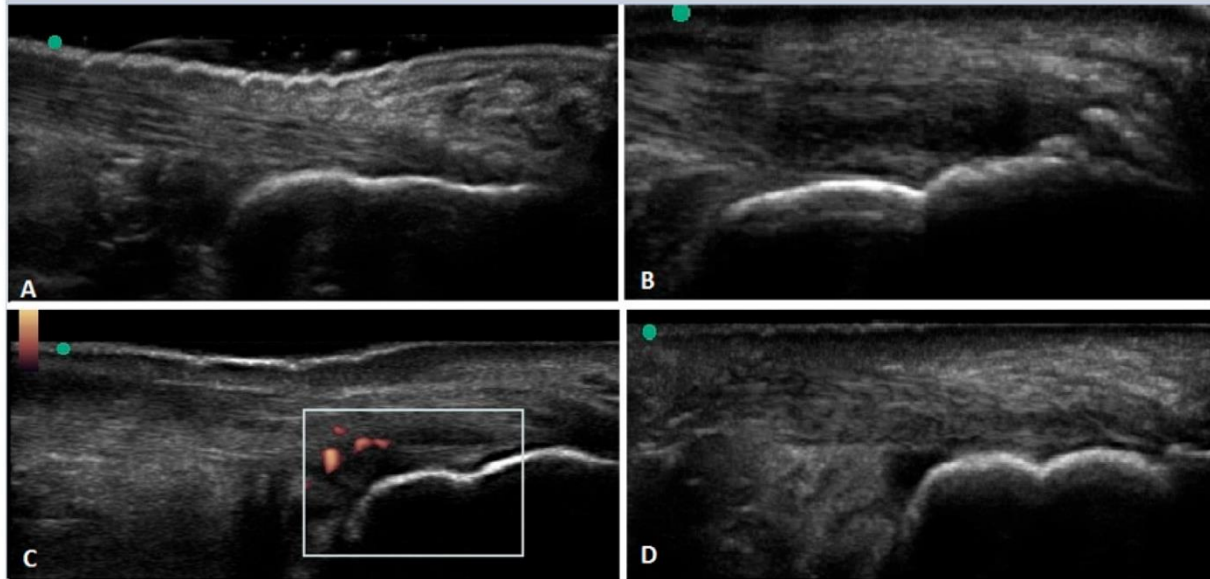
Ultrasound imaging of Achilles tendon. ^[56]
